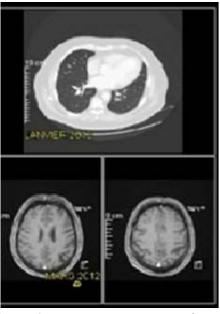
a CT scan and MRI confirmed the control of the metastatic disease
